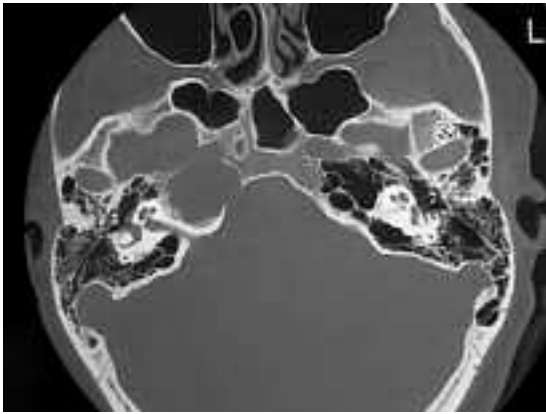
Axial CT scan with bone details shows hypodense smoothly-margined lesion of right petrous apex.
